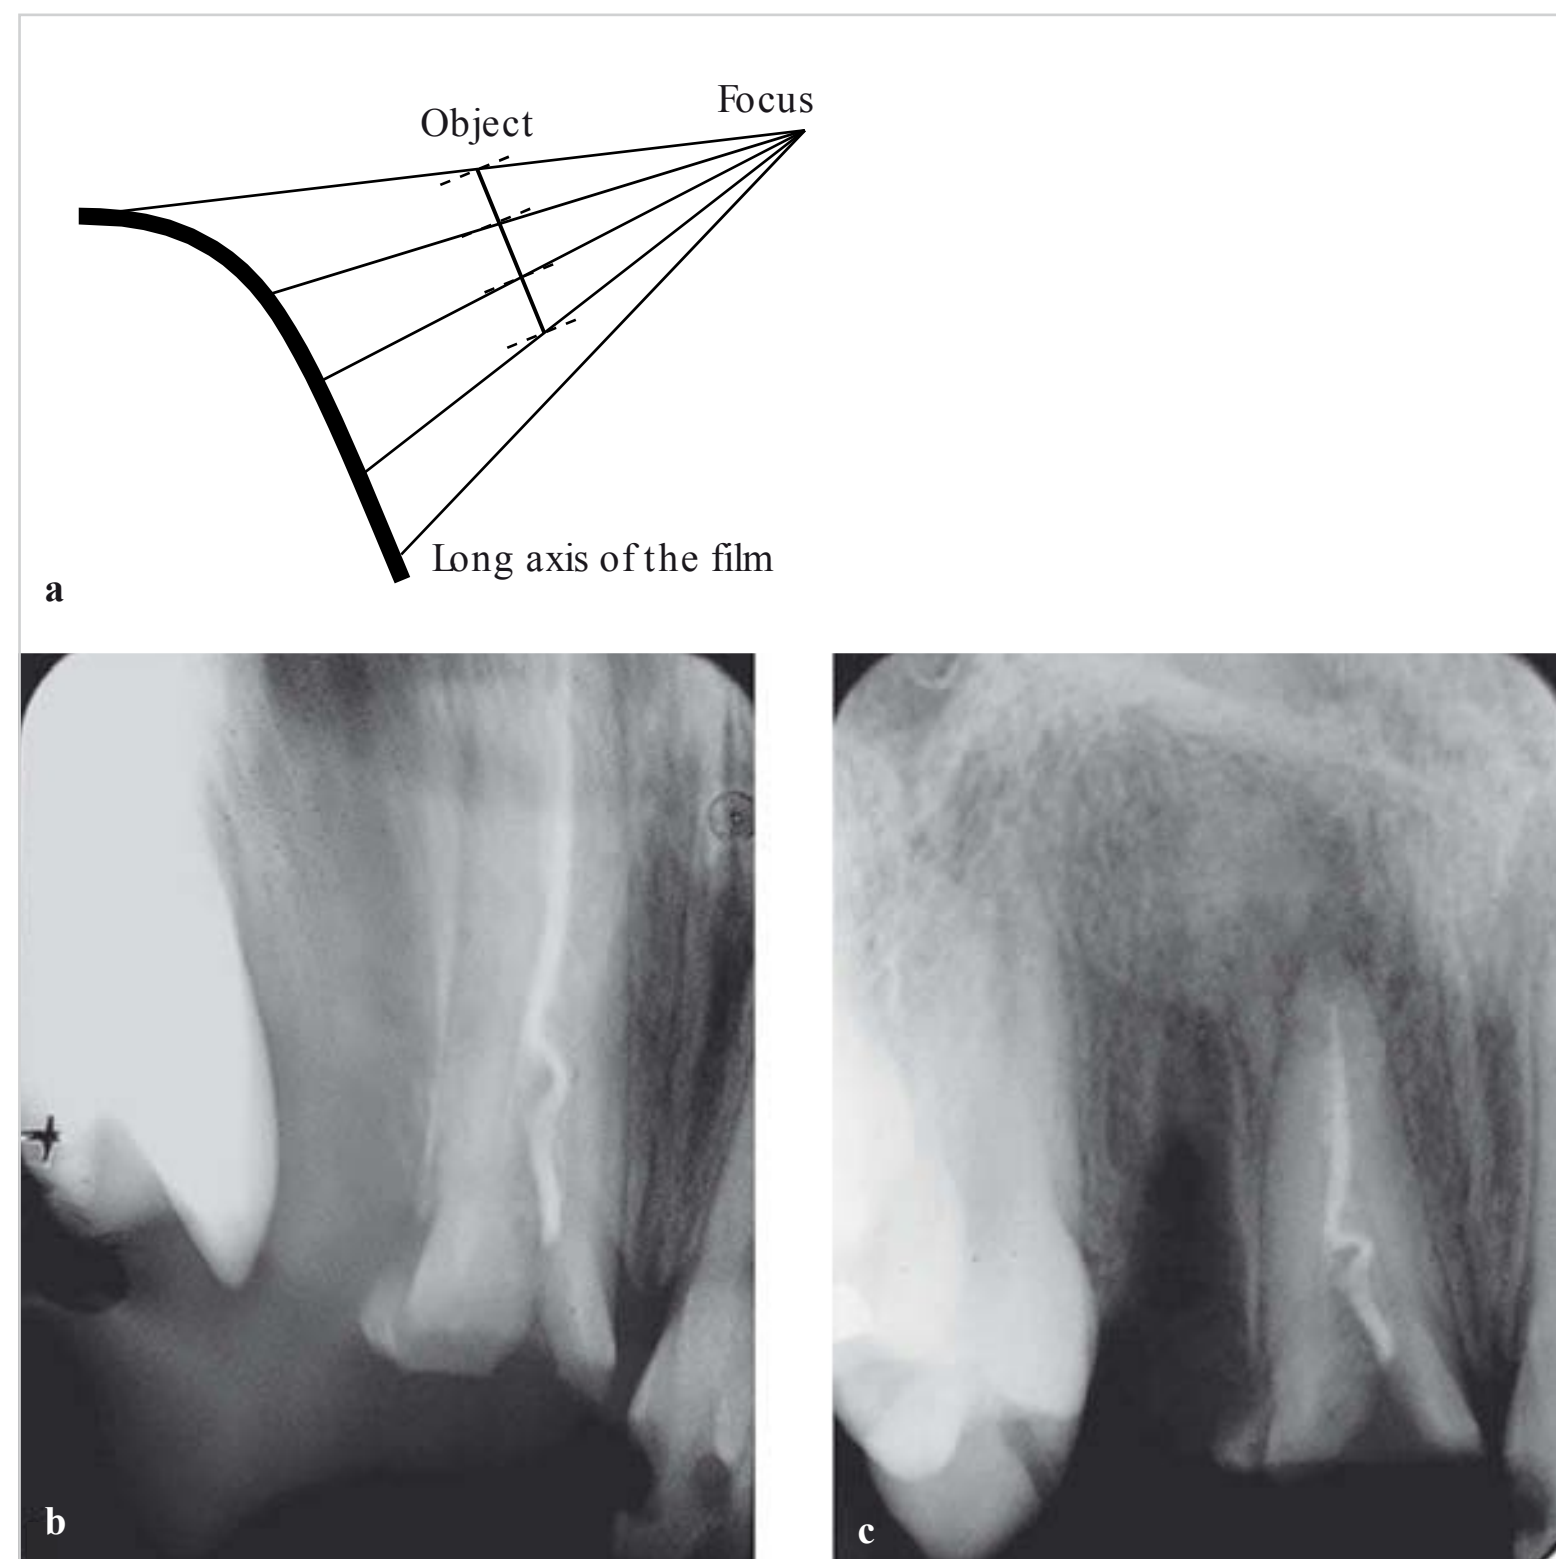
Radiographic distortion caused by bends in the film.
